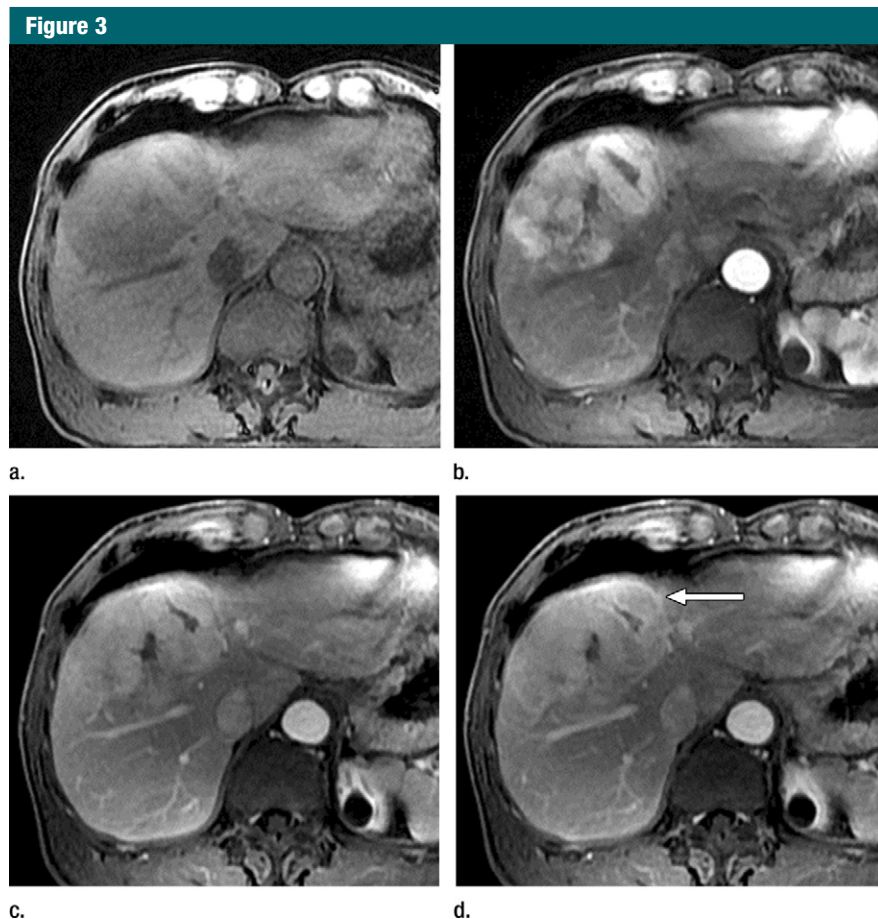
Images in 64-year-old man with HCC and hepatitis B-related cirrhosis: multiphasic MR technique with extracellular contrast agent. (a–d) Gadolinium-enhanced T1-weighted three-dimensional (3D) gradient-echo (GRE) images (repetition time msec/echo time msec, 6.3/1.9; flip angle, 15°) show large hypointense mass on (a) precontrast image with (b) hyperenhancement in late hepatic arterial phase. Notice enhancement of portal vein branches but not of hepatic vein branches in late hepatic arterial phase. (c) Portal venous and (d) 3-minute delayed phase images show persistent enhancement of tumor relative to liver. Persistent enhancement is atypical of large progressed HCCs, which characteristically appear to wash-out on venous phase images. Notice capsule appearance (arrow) on delayed phase image. Capsule appearance is seen to better advantage on delayed compared with portal venous phase image and permits confident diagnosis of HCC despite lack of washout appearance.
